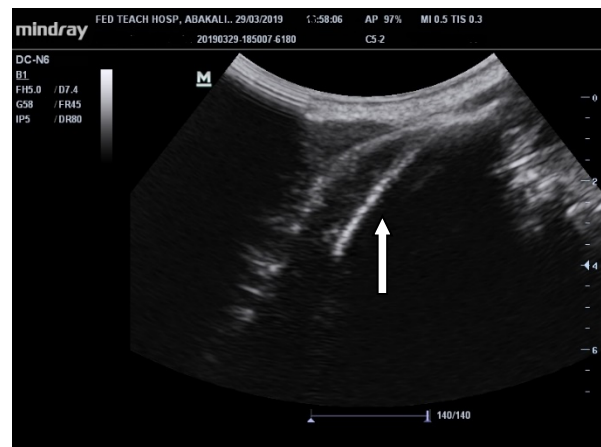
Longitudinal view ultrasonographic image of the posterior neck showing a linear hyperechoic structure suggestive of bone within the soft tissue of the neck. (white arrow)
